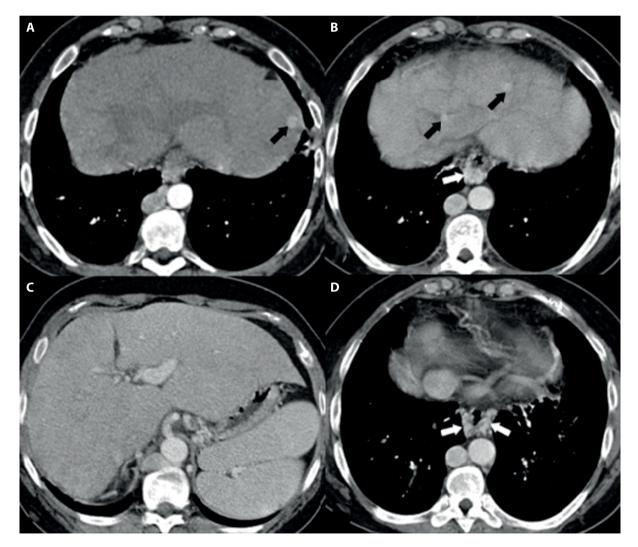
Upper abdominal CT scans show hepatomegaly with caudate lobe hypertrophy, patchy pattern of parenchymal enhancement, hypervascular nodules (nodular regenerative hyperplasia) (black arrows) and esophageal varices (white arrows).
